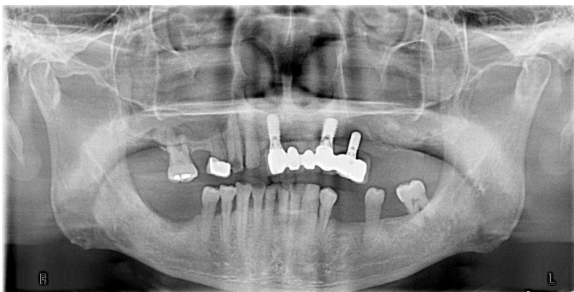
Orthopantomogram (OPG) of the patient.
